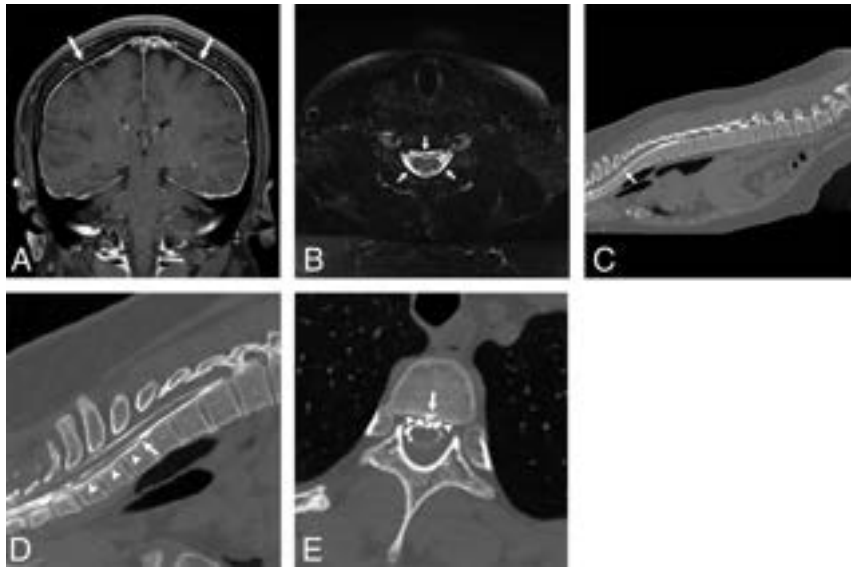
Detection of type 1 CSF leak with modified dynamic CTM in 2 scan acquisitions. *A*, Coronal contrast-enhanced fat-suppressed T1-weighted image shows dural enhancement (arrows) consistent with spontaneous intracranial hypotension. *B*, Axial fat-suppressed T2-weighted image shows ventral and dorsal extradural fluid (arrows) consistent with a CSF leak. *C*, Sagittal image from dynamic CTM after 3 mL of intrathecal iodinated contrast shows coating of the entire ventral spine, with a transition point at the T1–T2 level (arrow). *D*, Sagittal image from dynamic CTM after additional injection of 2 mL of contrast and scanning of the cervicothoracic junction only confirms a leak at the T1–T2 level, where there is a split in the contrast column (arrow) and extradural contrast layering dependently with gravity in the cervical spine (arrowheads). *E*, Axial image from the dynamic CTM shows that the CSF leak (arrowheads) is secondary to a ventral midline calcified disc (arrow).
